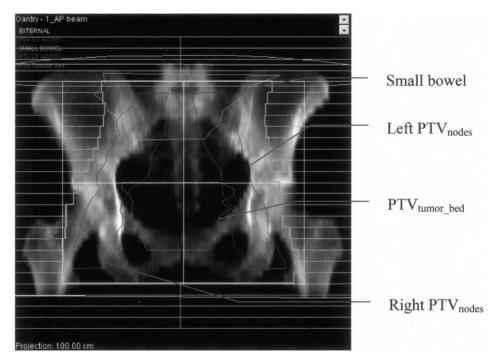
Digitally reconstructed radiograph in the anterior-posterior beam for the two-field conventional plan along with the projections of the planning target volumes ( PTV),  $PTV_{tumor\_bed}$ , left and right  $PTV_{nodes}$  as well as the small bowel.
